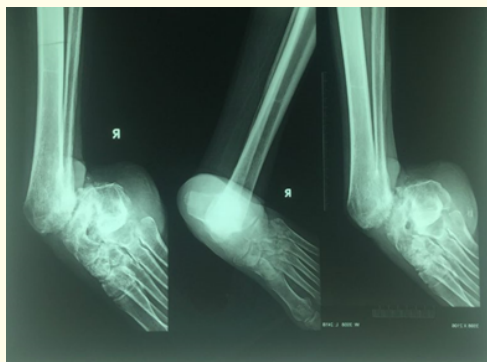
Radiograph AP lateral and Oblique showing Charcot deformity.
